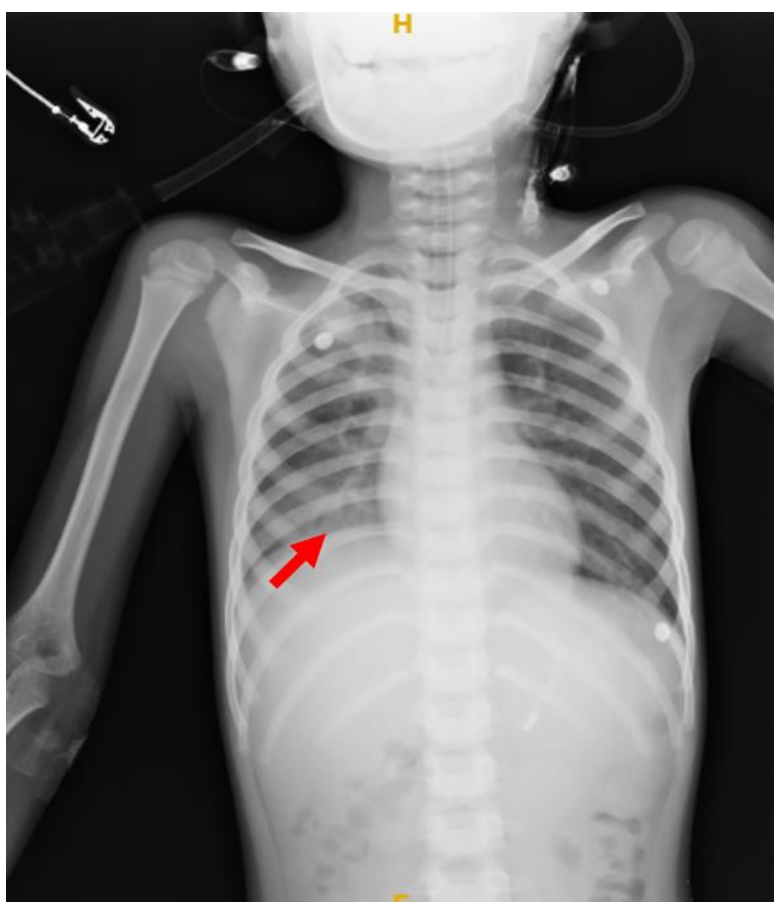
2D X-RAY of chest P-A view. The patient was subjected to a 2D X-ray of the thorax region to understand the degree of COVID pneumonia severity. Patchy opacities in the right lower lobe (red arrow) indicate pneumonia.
